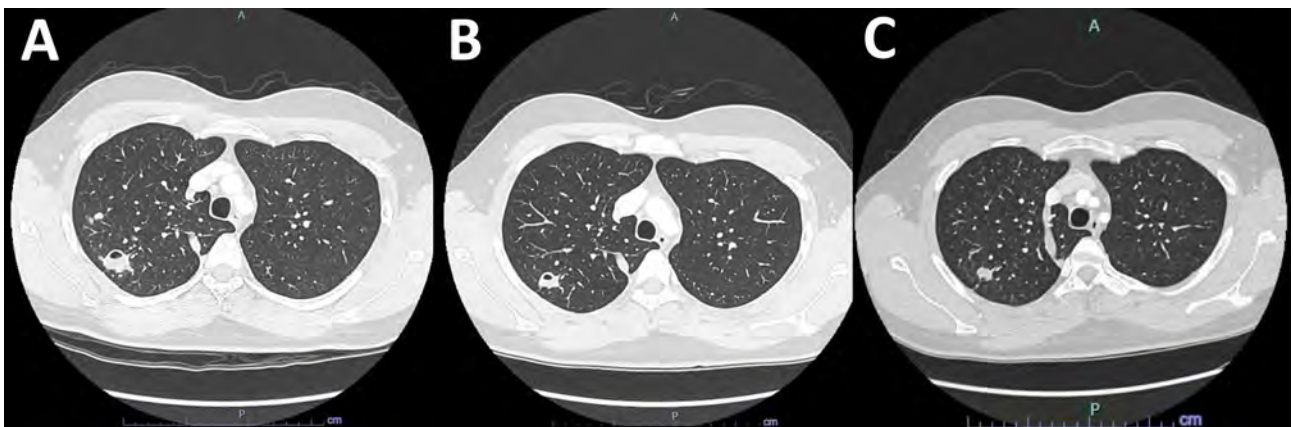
Computed tomography (CT) scans for reported case of *Tsukamurella tyrosinosolvens* infection in 25-year-old immunocompetent man. A) Initial CT showing 25-mm cavitating right apical lesion. B) Repeat CT after 6 months of treatment, indicating interval cavity reduction to 10 mm and resolution of the second smaller cavitation seen on original CT. C) Final CT 6 months after treatment cessation, indicating further cavity resolution without evidence of infection recurrence.
